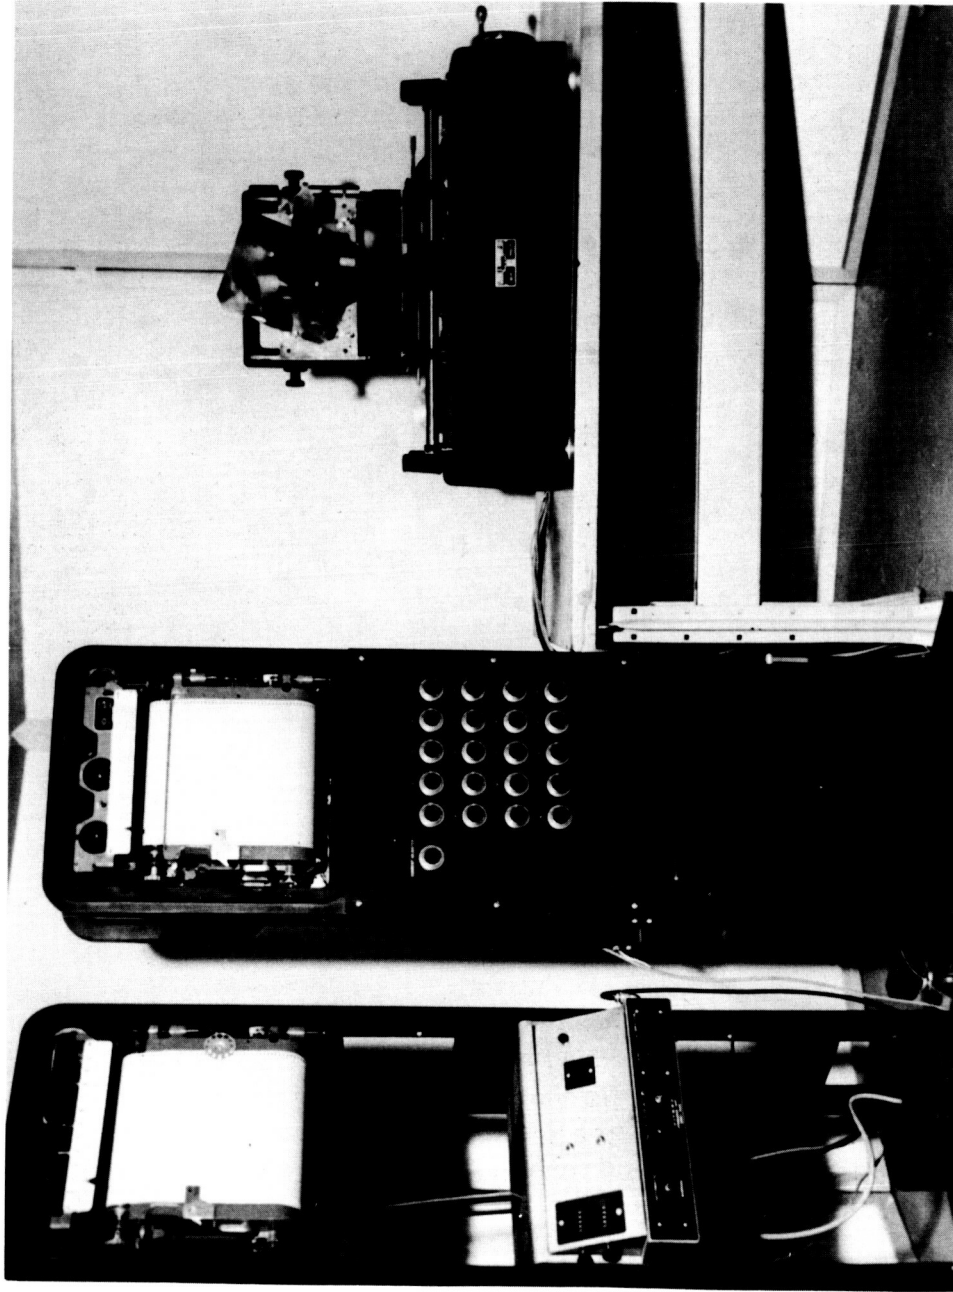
Densitometric assembly which is used to measure the equivalent calcium apatite mass in a section of bone penetrated by a scanning beam from a roentgenogram: right, densitometer; center, first recorder and potentiometer panel; left, second recorder and integrator.
